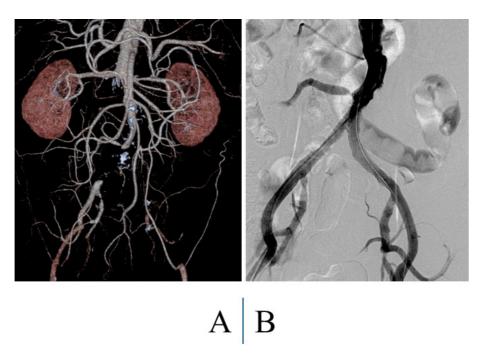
A 73-year-old male presented with bilateral intermittent claudication (200 m). CT revealed aorto-iliac occlusion (A). Completion angiography showed successful revascularization with stenting using the kissing balloon technique (B).
